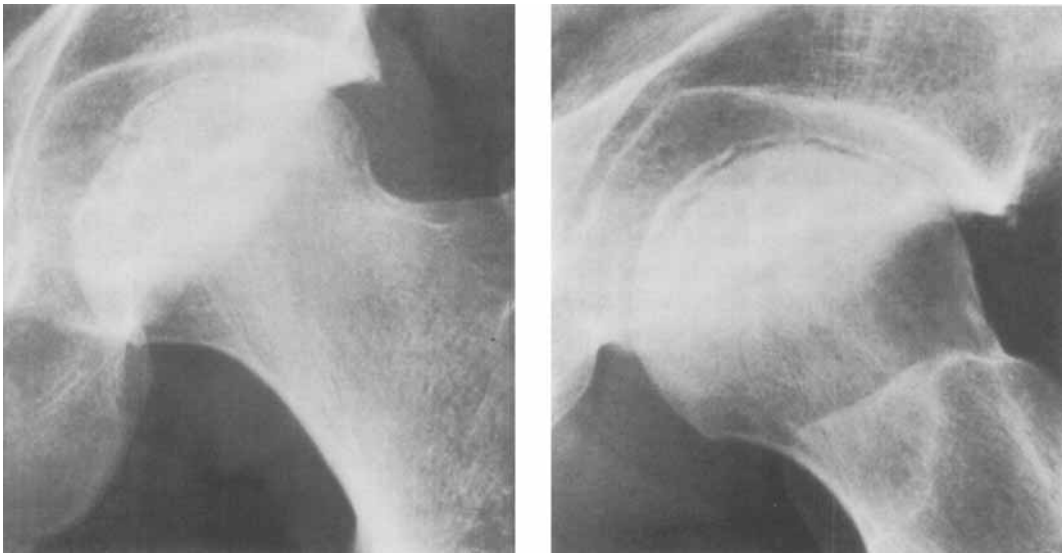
Osteonecrosis in the femoral head (a). Radiograph in the frog-like position (b) shows areas of increased density and radiolucencies, and fracture of the articular surface. Same patient as Figure 1, 4 years later.
